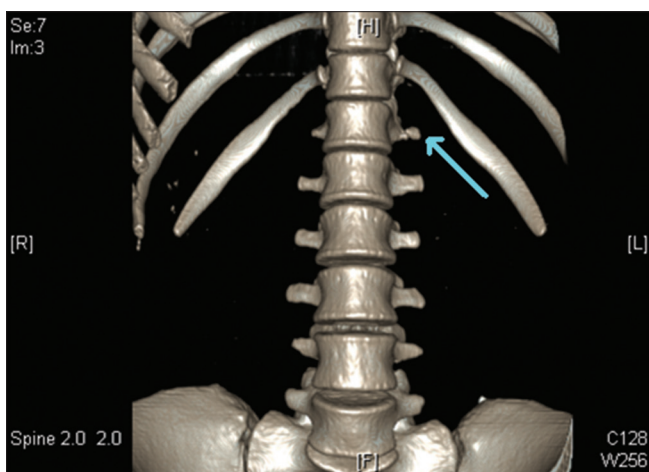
On the three-dimensional computed tomography imaging, left 12th hypoplastic rib (arrow) was observed while right one was not. Also left 11th costovertebral joint was subluxated
